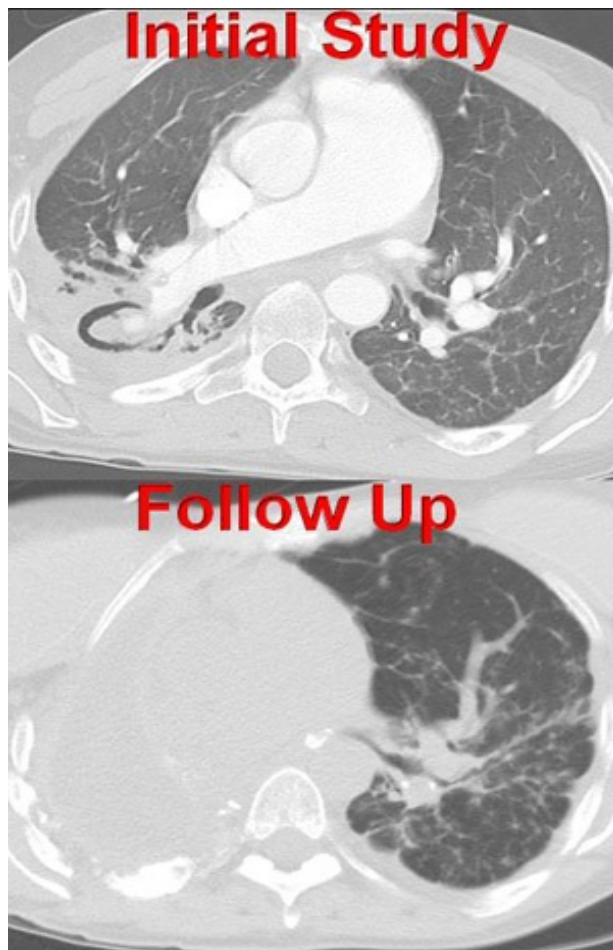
Axial thoracic CT at presentation (top image, part of the study shown in 2A) and later following right pneumonectomy when hemoptysis recurred (bottom image).
